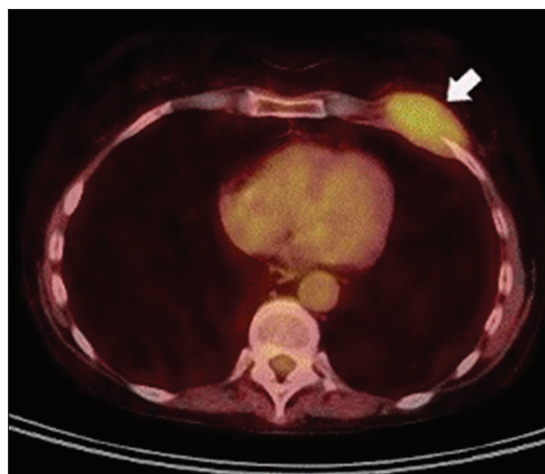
Axial positron emission tomography/computed tomography image of a patient with Gardner's syndrome demonstrating a hypermetabolic left anterior chest wall desmoid encasing an adjacent rib (arrow)
